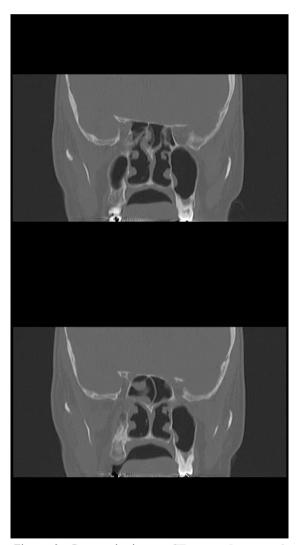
Paranasal sinuses CT scan. In coronal view shows mucosal thickening in ethmoidal air cells and sphenoid sinuses)
